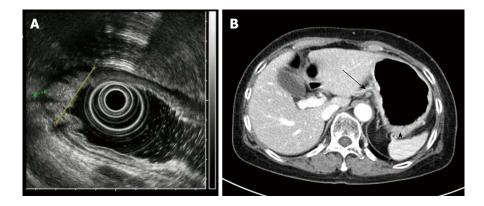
Endoscopic ultrasound shows subserosal invasion of the gastric lesion with lymph node involvement (A, B). Abdomen CT scan shows infiltrative gastric lesion involving cardia and angle of stomach (arrowhead) with enlarged perigastric lymph node (arrow).
